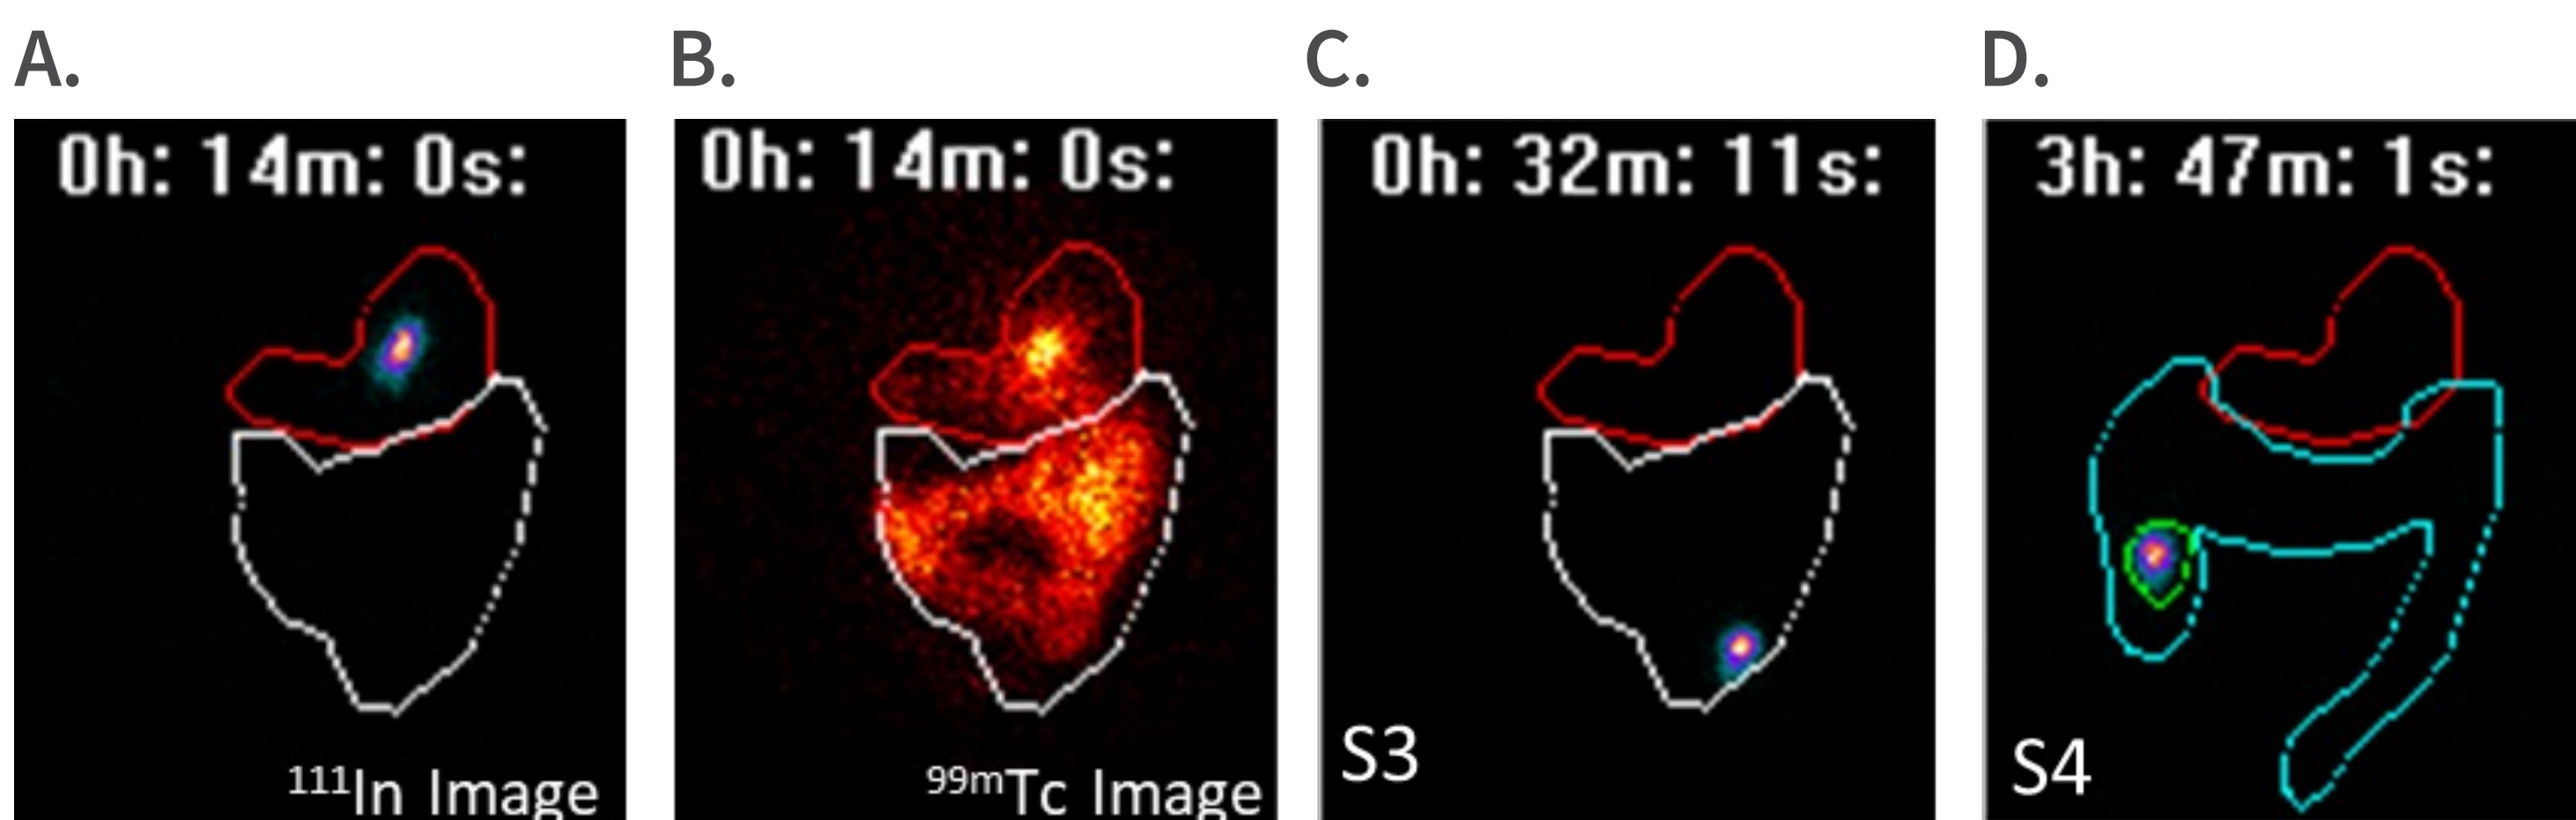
Gamma scintigraphy images of ¹¹¹In-DTPA in the DDS device and regions of interest in different GI segments with water containing ^{99m}Tc-DTPA co-administered with the devices. A. DDS device in the stomach; B. ^{99m}Tc-DTPA water delineated in regions of interest, including stomach (red) and proximal small intestine (white); C. DDS device (¹¹¹In-DTPA) at S3 detection in the proximal small intestine; D. DDS device (¹¹¹In-DTPA) at S4 detection in the colon (blue).
